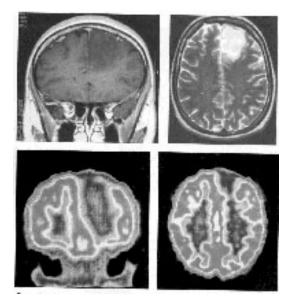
Shows a reduced uptake of ¹⁸FDG in the lesion seen on MRI images
